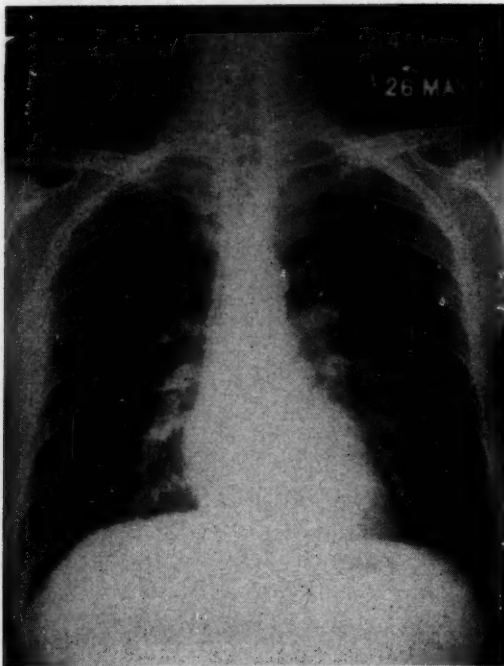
Case 5.* Chest roentgenogram, taken in May, 1958, prior to diagnostic lung biopsy. The changes are those of a diffuse reticulonodular infiltration.
